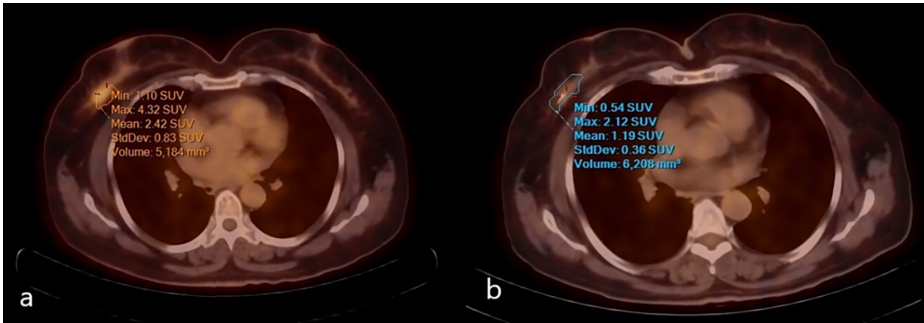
Changes in flourine-18 fluorodeoxyglucose positron emission tomography/computed tomography parameters at (a) baseline and (b) after neoadjuvant treatment of the same patient. This patient, whose ΔSUV_{max}, ΔSUV_{mean} changes were evident, had a pathologic complete response according to pathology. SUV, standardized uptake value.
